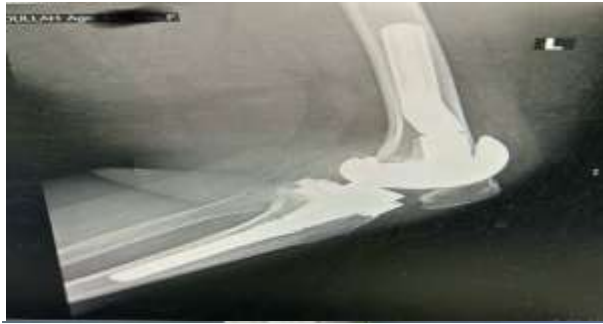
Pre-operative X-ray: anteroposterior (AP) and lateral views and tele-radiography.
